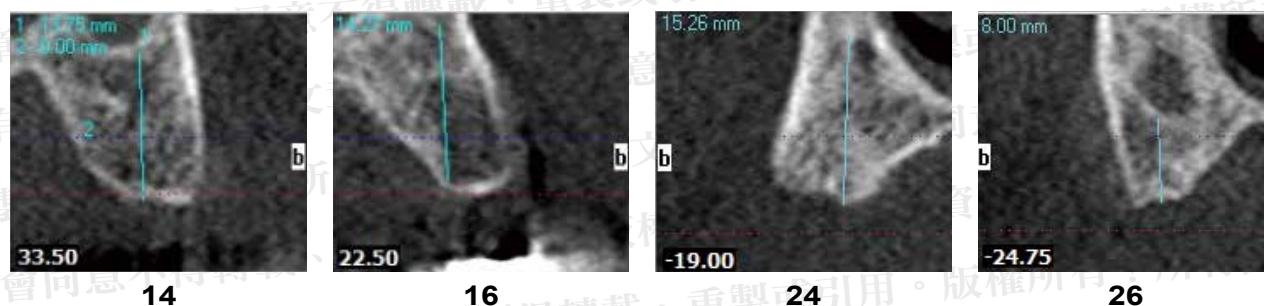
Cone beam computerized tomographic scan showing sufficient amount of alveolar bone for installing implants over the 14, 16, 24, 26 areas.
